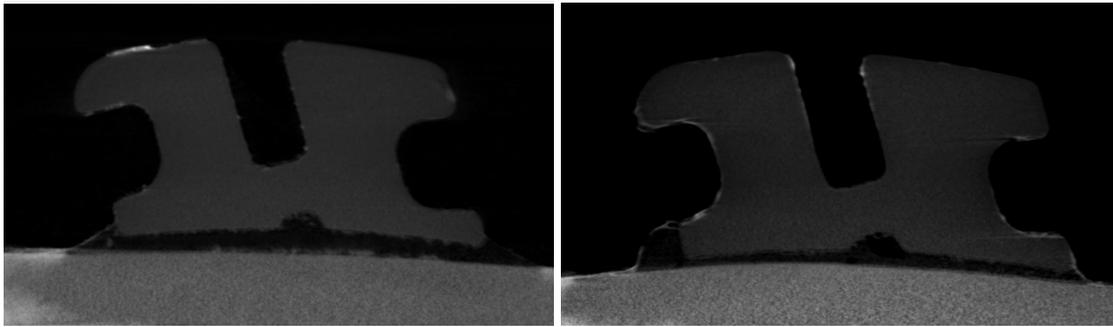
Micro-computed tomography scans showing the adhesive layer of brackets bonded with the flash-free (left) and the conventional adhesive (right). Radiopaque silver nitrate deposits are visible on the outer surface of the brackets, especially the gingival tie wings.
